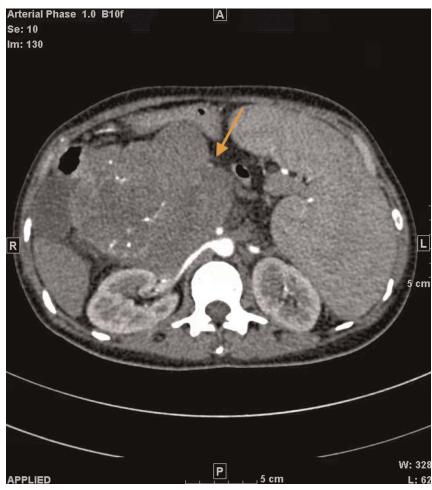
The transverse section of pancreatic thin-layer computed tomography reveals an irregular solid and cystic mass (12.3 cm \times 9.3 cm \times 8.0 cm) in the pancreas head with a lobulated appearance (arrow).
